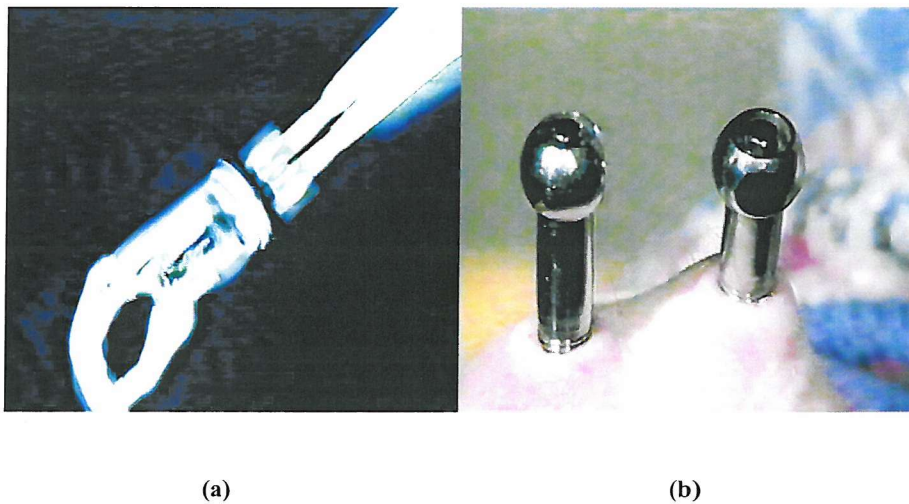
Osseointegration: (a) X-Ray of Titanium Implants and Prosthesis, (b) Titanium Implants at the Skin Surface
